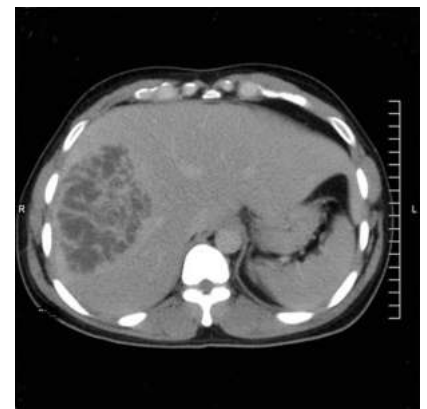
CT of the abdomen with contrast enhancement revealing a multiloculated, rim-enhancing hepatic abscess. (Adapted with permission from Casella F, Finazzi L, Repetti V, et al. Liver abscess caused by *Klebsiella pneumoniae*: Two case reports. *Cases J*. 2009;2:6879.)
